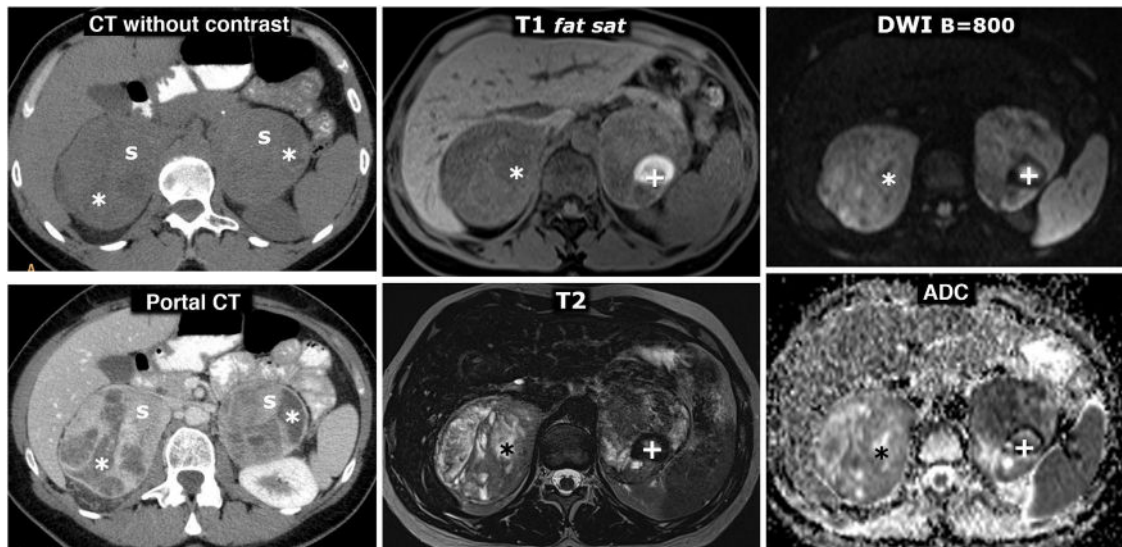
MEN2A syndrome with bilateral pheochromocytoma and millimetre-sized medullary thyroid carcinoma (not shown, two foci identified in prophylactic total thyroidectomy). 42-year-old female who consulted for episodes of hypoglycaemia. Left column, CT: two large and well-defined adrenal masses, with intensely enhancing solid areas(s), and other cystic areas (*) without significant enhancement. Two columns on the right, MRI: respective adrenal masses, with some foci of especially high signal on T2, corresponding to foci of cystic degeneration (*) and an area with high peripheral signal on T1, with very low signal on T2 (+), which corresponds to a focus of old haemorrhage with peripheral deposit of haemosiderin.
